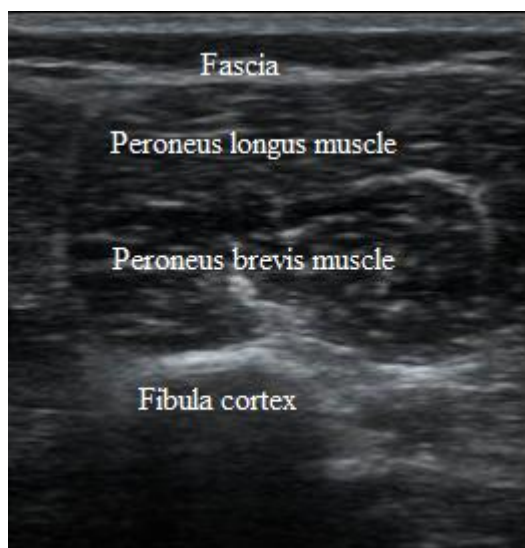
Lateral Compartment Transverse Ultrasound View.
